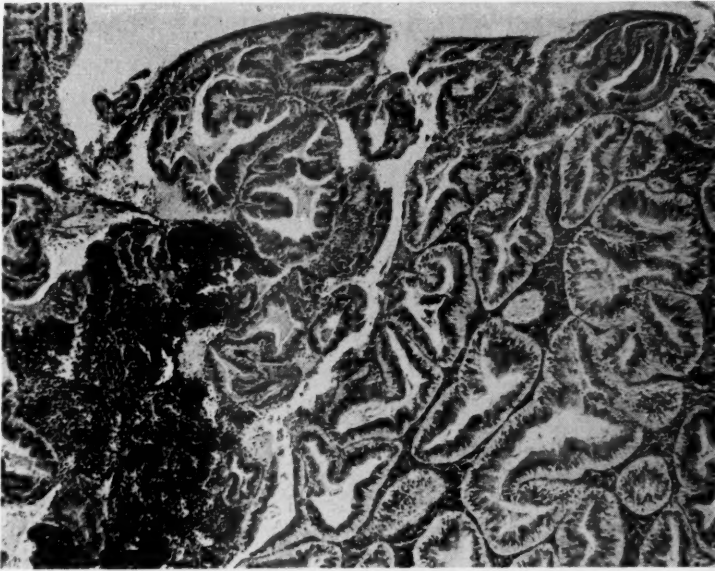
Pseudomalignant hyperplasia in woman 49 years of age, who had only curettage and x-ray induction of menopause one year previously. No bleeding since then. Note tall, well-differentiated epithelium with small needlelike nuclei.
